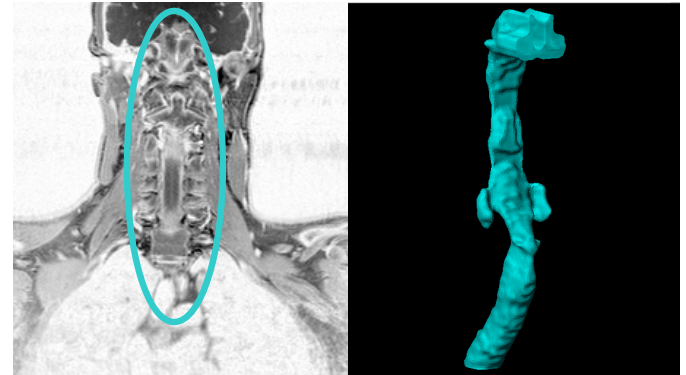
MRI scan (left) and segmented airways (right)
